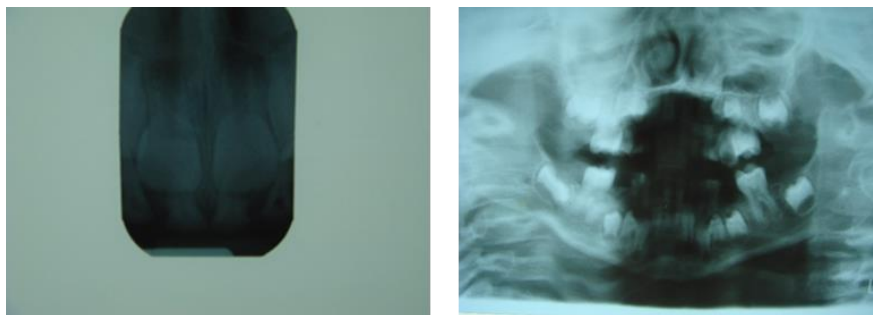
X ray radiographs of case-2
